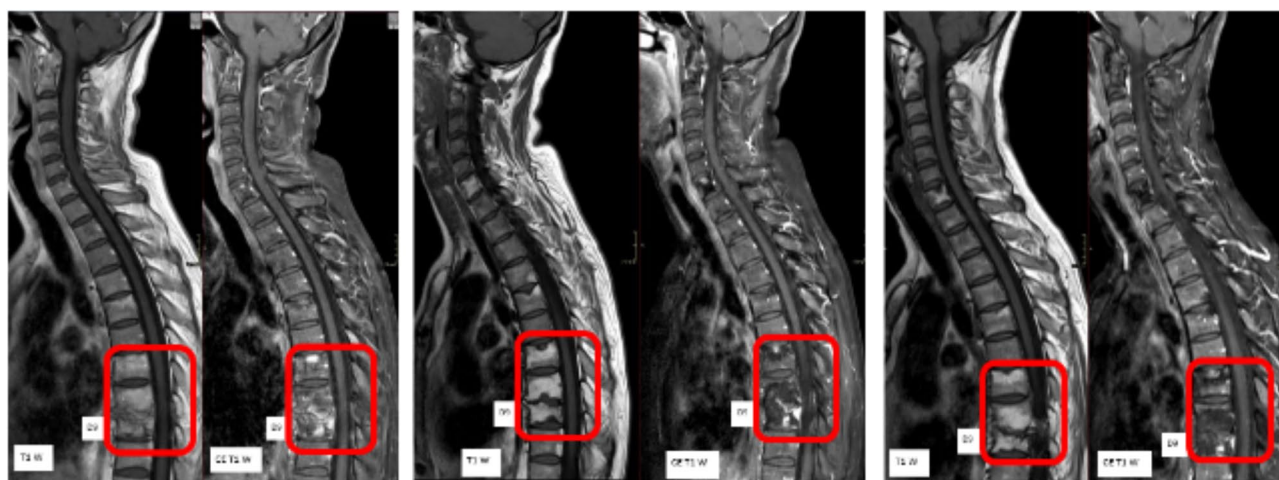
(A) MRI showing improvement of spinal lesions. (B) MRI showing further improvement of lesions with persistence of D8-D9 enhancement of reduced intensity. (C) MRI showing stable findings
